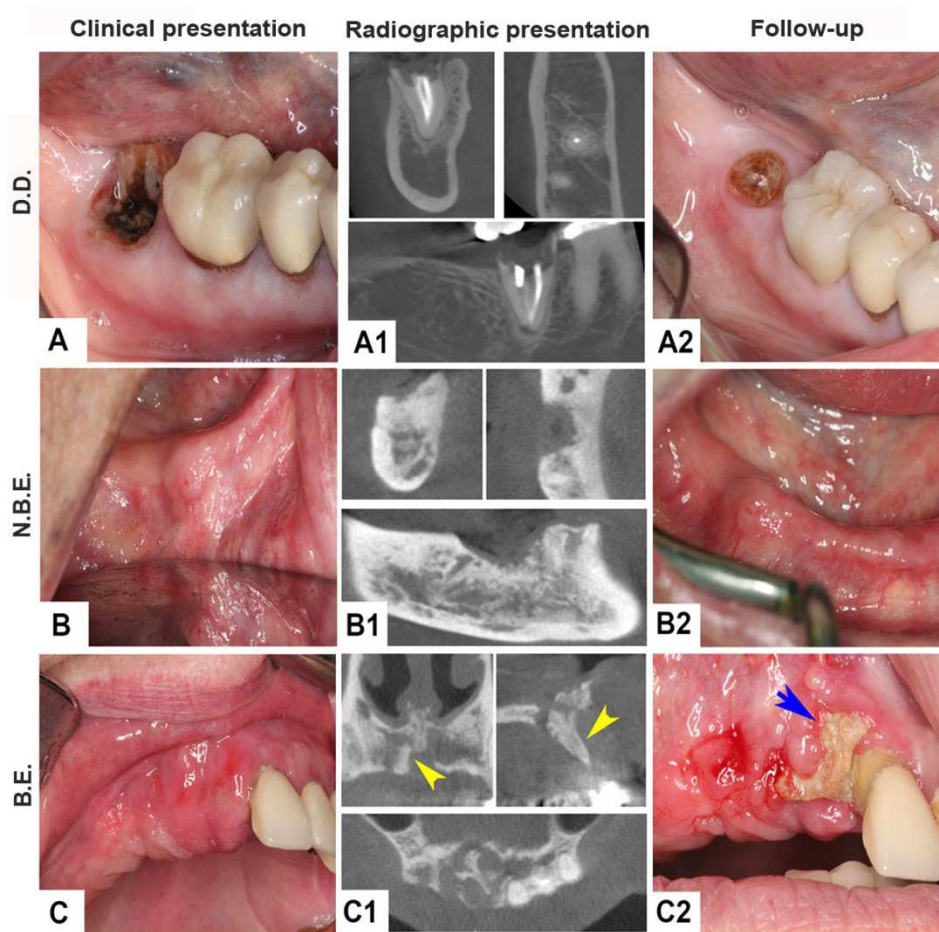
Clinical and radiographic evaluation at initial presentation and clinical follow-up. Initial clinical and radiographic presentation and clinical follow-up of a patient who was classified as a dental disease (D.D.) case (A, A1, A2), a patient with stage 0 MRONJ and no progression to bone exposure (N.B.E., B, B1, B2) and a patient with progression to bone exposure (B.E., C, C1, C2). Yellow arrowheads point to areas of sequestration. Blue arrow points to bone exposure.
